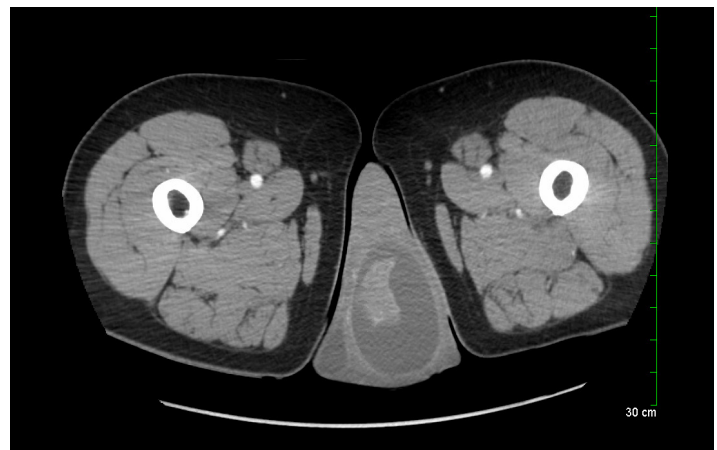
CT abdomen and pelvis with IV contrast showing scrotal edema and left hydrocele exerting mass effect on the testicle, consistent with epididymo-orchitis and pyocele.
